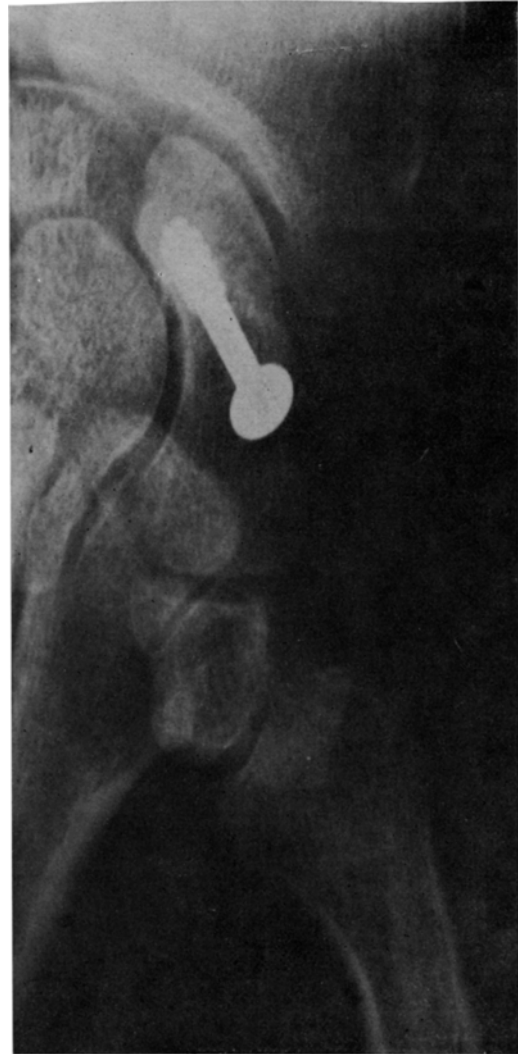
Radiograph at seventeen months shows healing of fracture and more uniform density through the scaphoid bone.
